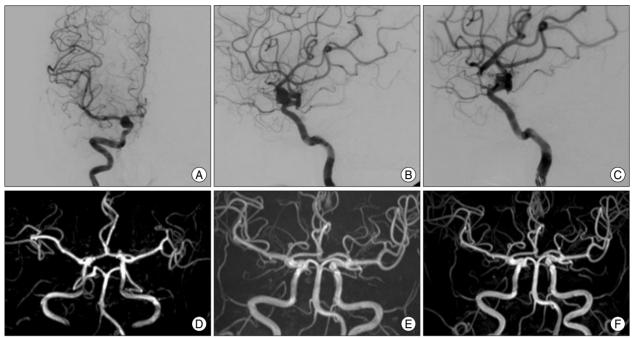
Preoperative anteroposterior (A) and lateral (B) right carotid artery (CA) angiogram, revealing a dorsal wall aneurysm arising from the distal portion of the ophthalmic artery. Final lateral angiogram (C) after detachable coil embolization confirmed a small residual neck of the aneurysm. About 6 months later, follow-up 3D time of flight (TOF) magnetic resonance images (MRI) (D) shows that the small residual neck of the dorsal wall aneurysm is suspicious. Post-embolization 3D TOF MRI (E) taken one-and-half year later shows no definite residual sac. Post-embolization magnetic resonance angiography (F) performed at two-and-half year later confirms no definite residual sac or neck.
